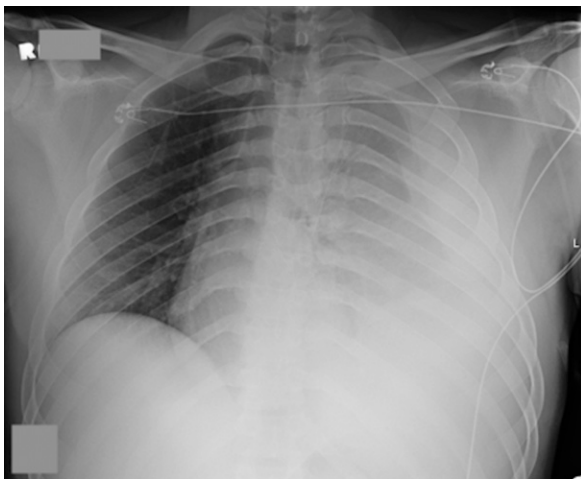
Chest radiograph of massive left hemothorax.
